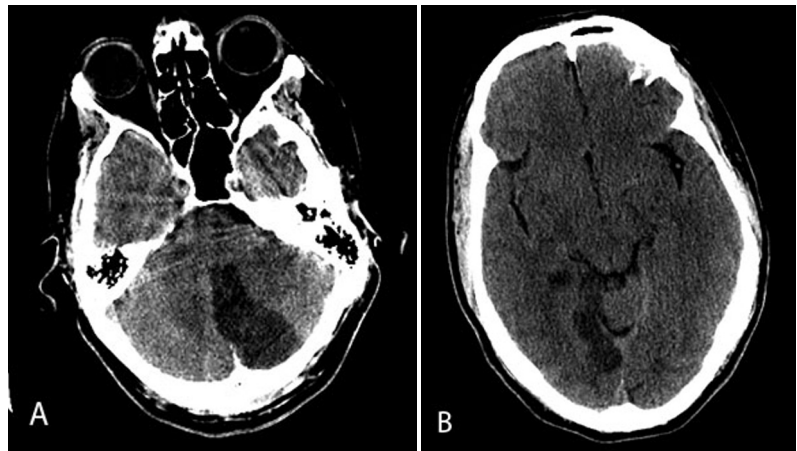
54-year-old male with subclavian artery dissection. CT of the head. Hypodensity in the left PICA distribution (A) and the right occipital lobe (B) that is secondary to acute infarction.
